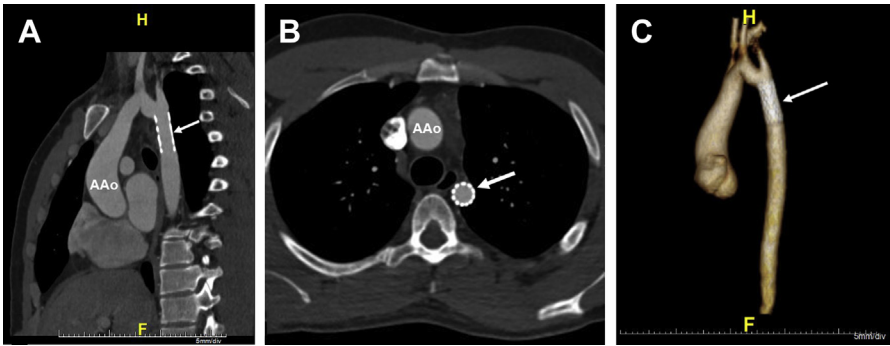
Computed tomography angiography of the aorta in oblique sagittal (A) and axial (B) planes demonstrating no evidence of in-stent stenosis (arrows) in a 32-year-old patient with coarctation who underwent previous end-to-end anastomosis and later required transcatheter therapy for recoarctation. 3D reconstruction (C) displays the luminal contour of the Palmaz stent.
